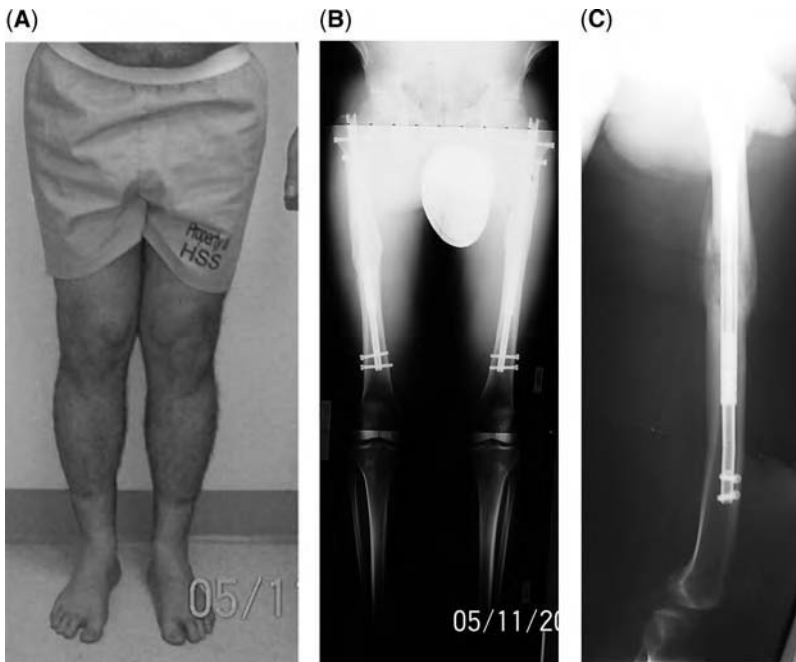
Case example of a 5 cm stature lengthening using ISKDs in bilateral femurs. (A) Clinical photo at the end of distraction. (B) Erect leg radiograph at the end of distraction. (C) Lateral radiograph of the right femur showing the progression of healing. *Abbreviation:* ISKD, intra medulla skeletal kinetic distractor.
